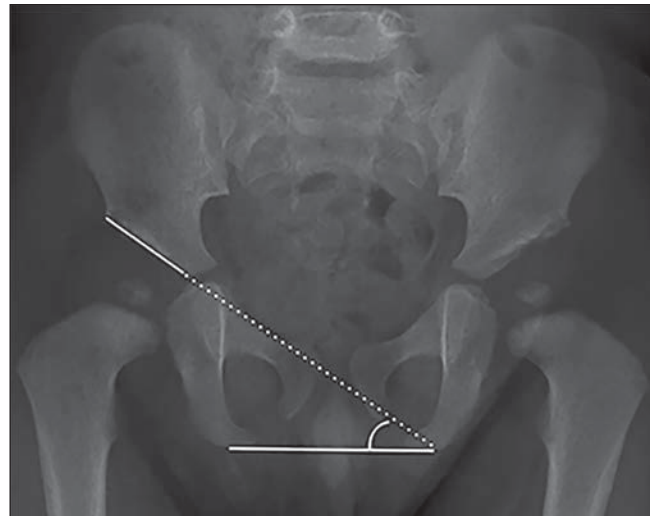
20-month-old healthy boy with bilateral developmental dysplasia of hip. Anteroposterior pelvic radiograph shows alternative method of assessing acetabular index by measuring angle between line connecting lowest points of ischial tuberosity (*solid line*) and line connecting inferomedial acetabular edge and superolateral edge (*dotted and solid line*).
